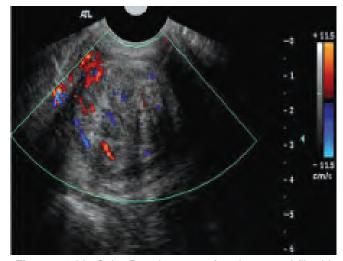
Color Doppler scan of an intramural fibroid
